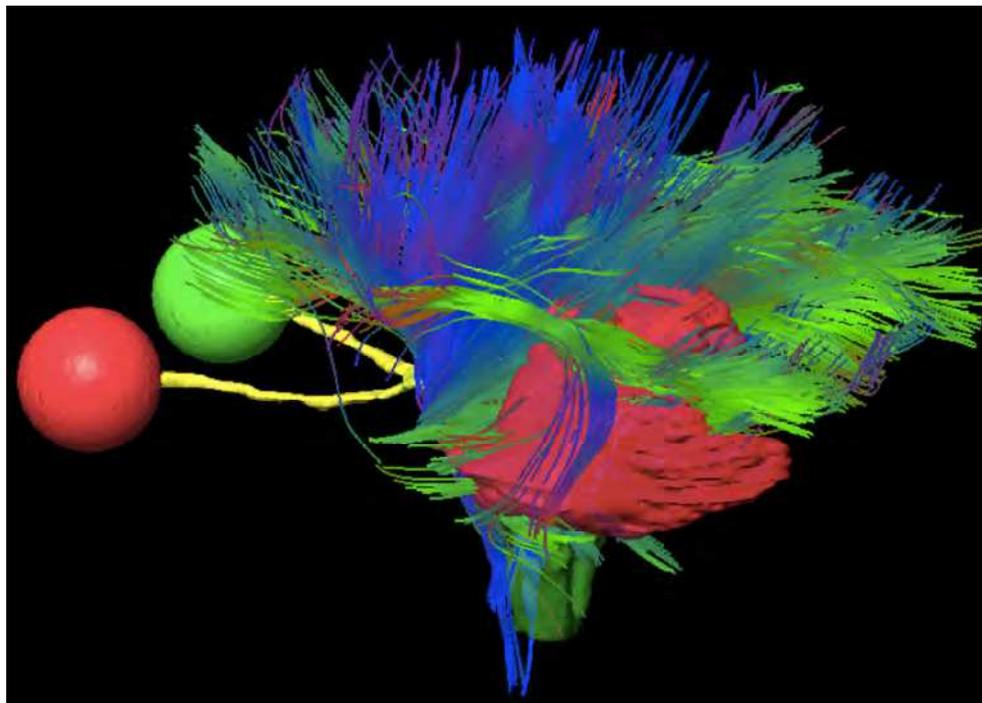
Tractography. 3-Dimensional reconstruction showing fiber tracts generated from DTI MRI sequence in a patient with large glioblastoma multiforme.
